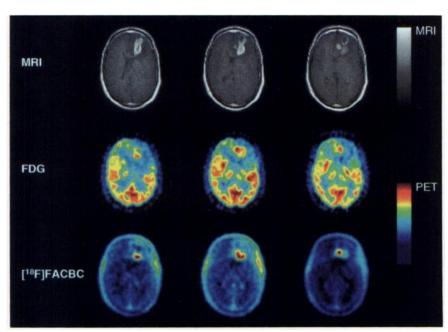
Patient with glioblastoma multiforme. T1-weighted transaxial MRI scans with gadolinium enhancement taken before surgery show lesion throughout left frontal lobe with extension over midline (top row). FDG PET images taken 8 wk after surgery (middle row). PET images using [18F]FACBC taken 1 wk after surgery show residual tumor (bottom row).
